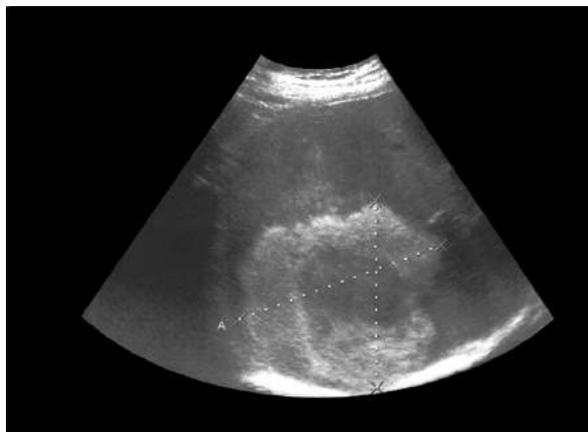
Ultrasound showing a giant hyper echoic tumor within the right lobe of the liver
